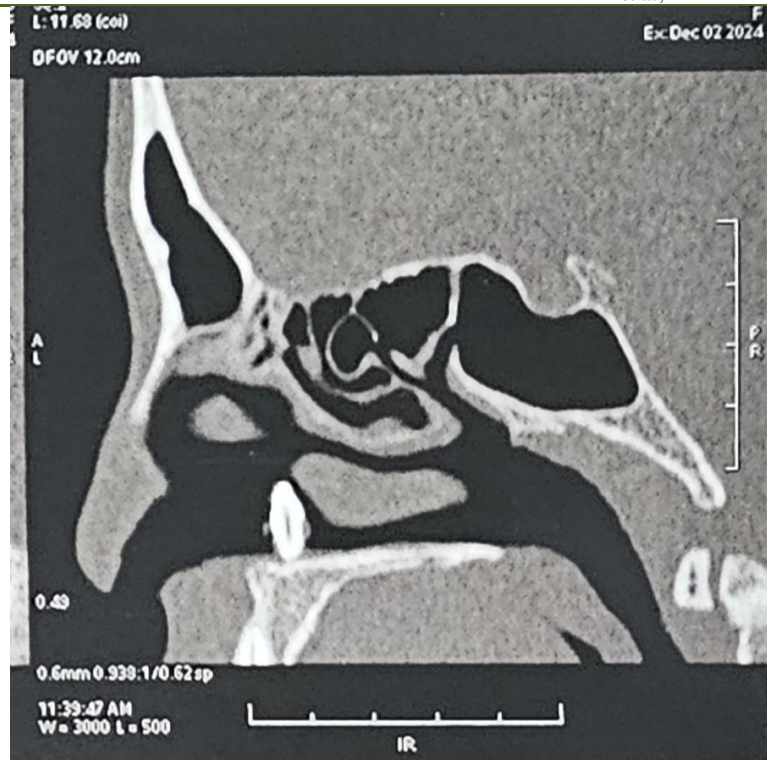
Sagittal CT of the nasal cavity showing a tooth-like radiopaque lesion near the nasal floor and hard palate region
